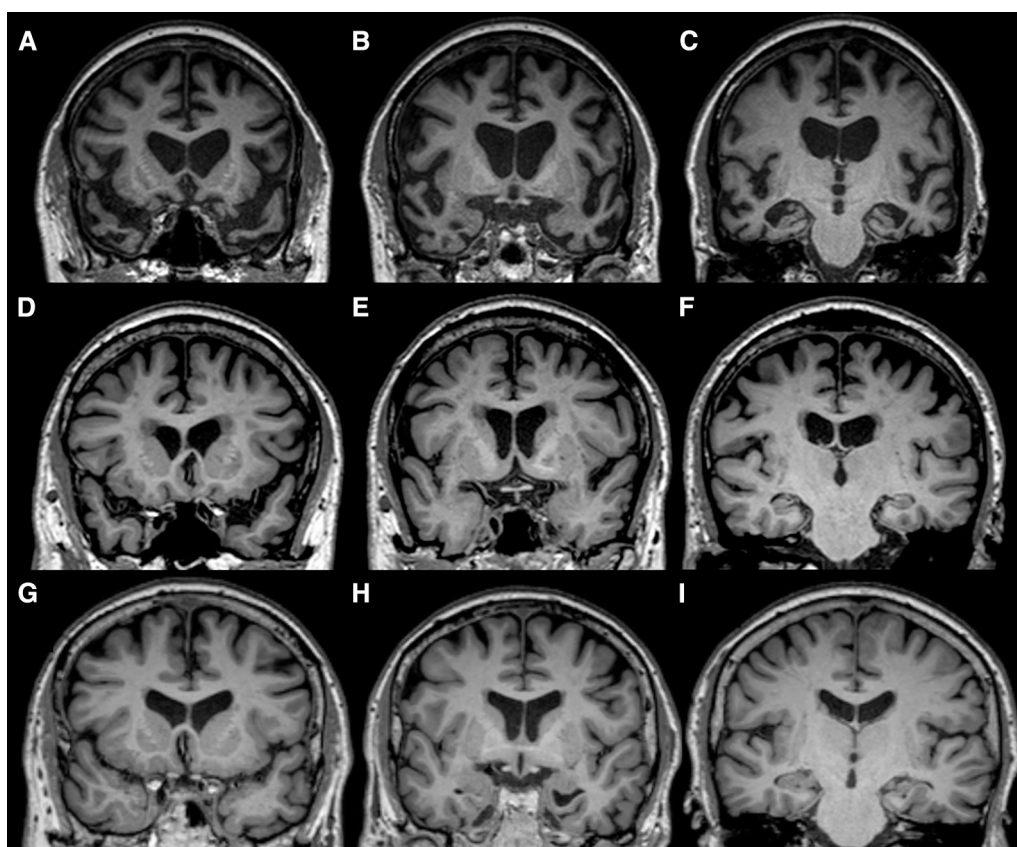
MRI appearances of globular glial tauopathy (GGT). T1 coronal MRI from patient 2 (first row), a non-GGT FTLD tauopathy (second row), and an age-matched control subject (third row). First row: Sequences taken through the anterior temporal (A), mid-temporal (B), and posterior temporal (C) regions of patient 2. The anterior poles and mesial aspects of the temporal lobes were affected bilaterally, with no significant asymmetry. The dorsolateral prefrontal, interhemispheric, and orbitofrontal cortices were affected bilaterally, again with no particular asymmetry. Second row: A similar pattern of frontal and temporal lobe atrophy is appreciated in a case of pathologically confirmed non-GGT FTLD tauopathy (D–F). Third row: a control subject with normal frontal and temporal volumes (G–I).
